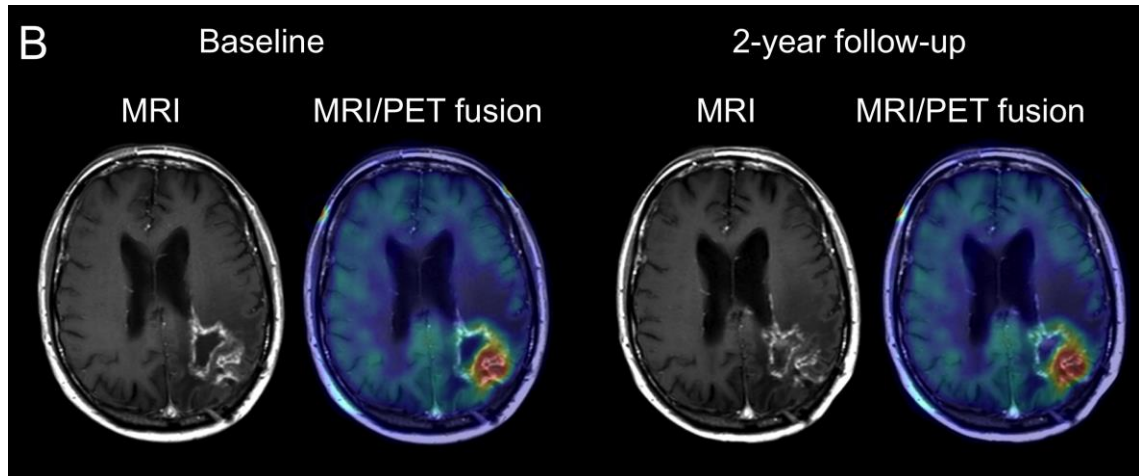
T1-Gad MRI and MRI/AMT-PET fusion images of a left parieto-occipital tumor. The PET+ area was congruent with the bulk of the Gad+ lesion; no progression during the 2-year follow-up; SUV_{max} was below 4 (3.8).
